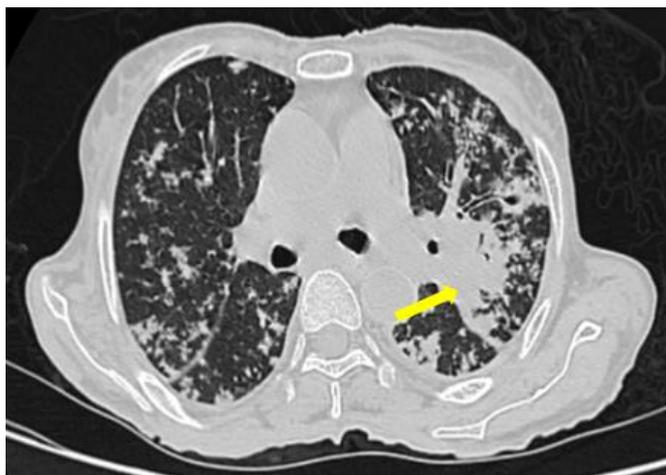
CT thorax of Case 2 showing diffuse consolidation in both upper lobes, cavitation in the basal region of the right lower lobe and a tree-in-bud pattern in the bilateral lung parenchyma. A yellow arrow indicates consolidation in the left lung.
